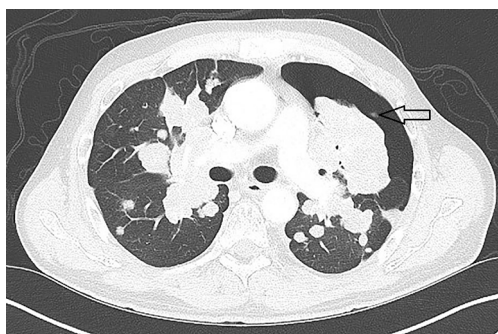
CT chest of a patient with breast cancer and malignancy-associated secondary spontaneous pneumothorax (arrow). CT, computed tomography.
